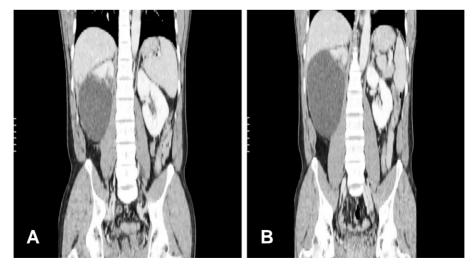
(A) Follow-up CT scan at 1 month after injury shows large cystic mass at right perirenal with enhanced thick wall and hounsfield unit inside mass is 14~26. (B) Follow-up CT scan at 3 months after injury shows large cystic mass at right perirenal with enhanced thin wall and hounsfield unit inside mass is -12~2
